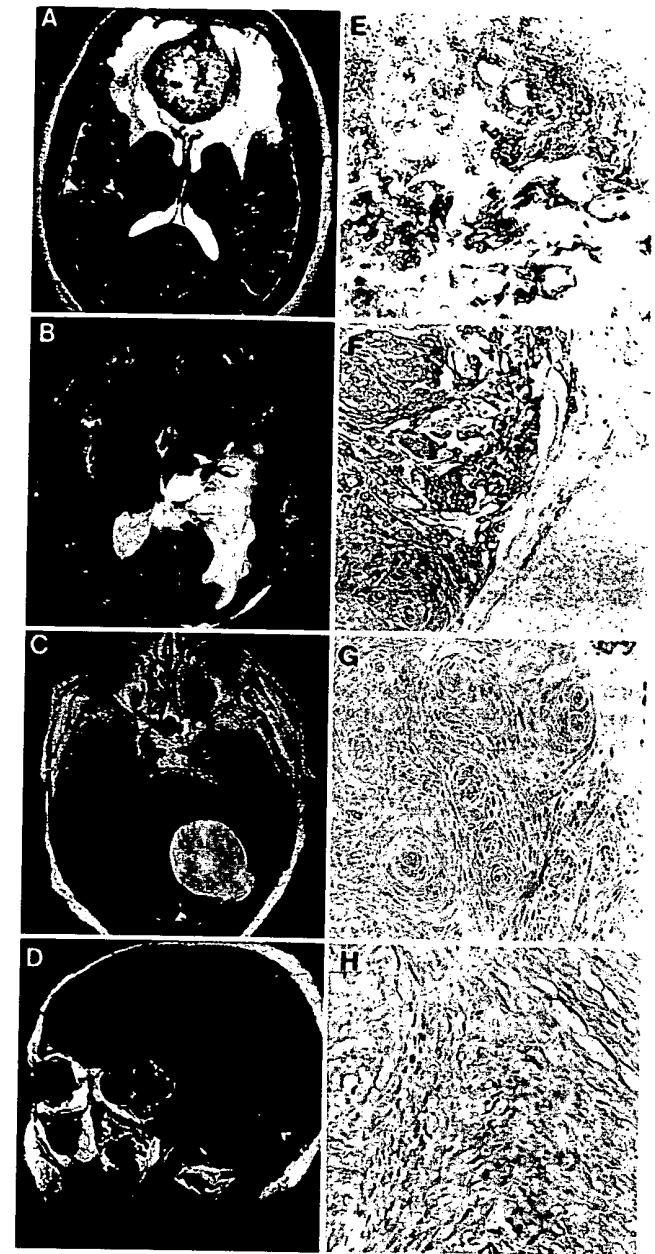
Representative preoperative MRI images (left panels) with the corresponding tumor tissue resected from the same patient (right panels) and tested for immunoreactivity for VEGF/VPF. These selected images demonstrate the range of edematous changes estimated from T2- or T1-weighted MRI scans (Panels A–D), as well as the differences in intensity and distribution of monoclonal antibody 5C3.F8 binding (Panels E and F).
